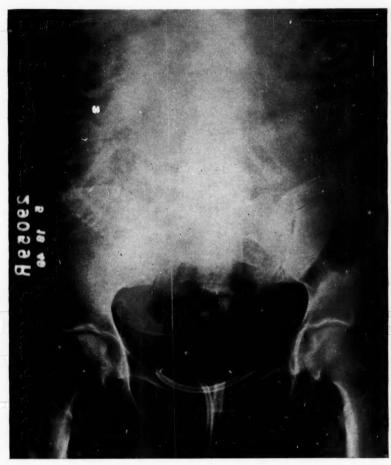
E. B., H.K.H. No. 101720, a 33-year-old gravida vii, para vi, had x-ray placentography because of slight vaginal bleeding. The placenta is seen to be implanted in the left cornual-fundal region, and the fetal head is presenting while the breech occupies the right half of the fundus. Although this patient was at term it was noted on rounds that her fetus might possibly undergo spontaneous version to breech presentation because of the left cornual-fundal implantation of the placenta. She was discharged and readmitted three days later in labor, and had a spontaneous breech delivery, the breech presenting left sacroanterior. The placenta, we know from our experience with x-ray placentography, lies in that portion of the area within the uterine wall outline which is not occupied by any fetal parts. This case exemplifies the positive effort of the fetus to accommodate itself best to the shape of the amniotic sac, i.e., the shape of the available fetal space.
